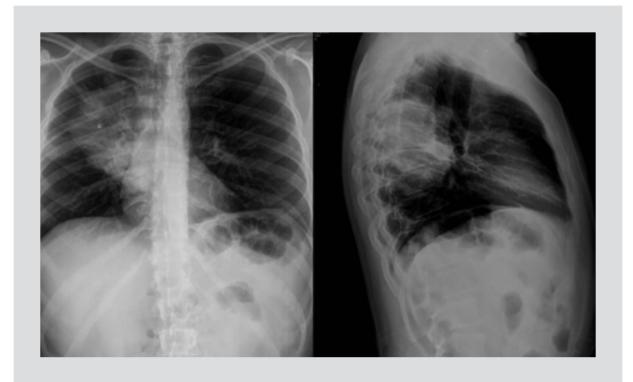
AP and lateral X-ray. Large, rounded parahilar opacity with well-defined margins.
